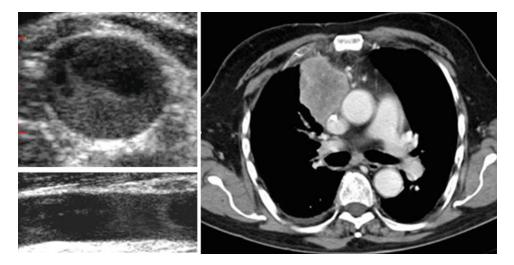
Intrathoracic lymphoma (CT scan, *right panel*) leading to superior vena cava syndrome with marked stagnation of flow in the jugular vein (*left panel*)
